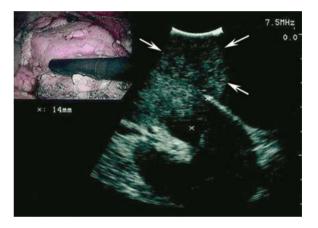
Laparoscopic intraoperative real-time ultrasound. Intraoperative US image shows the tumor outlined by *arrows* and 14-mm distance of inner margin of tumor from caliceal system marked by two cursors (*x*). *Inset* shows picture-in-picture capability that allows visualization of location of laparoscope probe on tumorous kidney.
